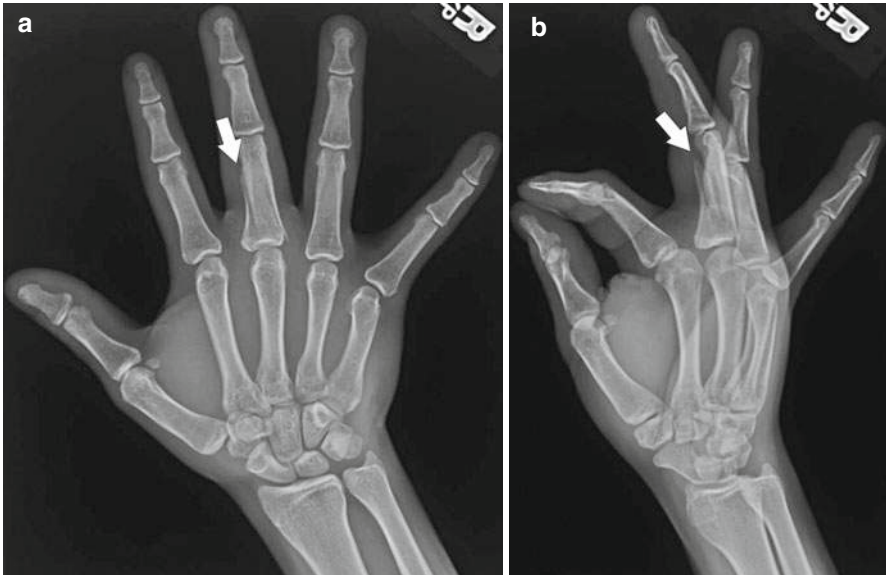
Phalangeal fracture. Hand X-ray posteroanterior (a) and semipronated oblique (b) views reveal a comminuted fracture (arrows) of the third proximal phalanx
